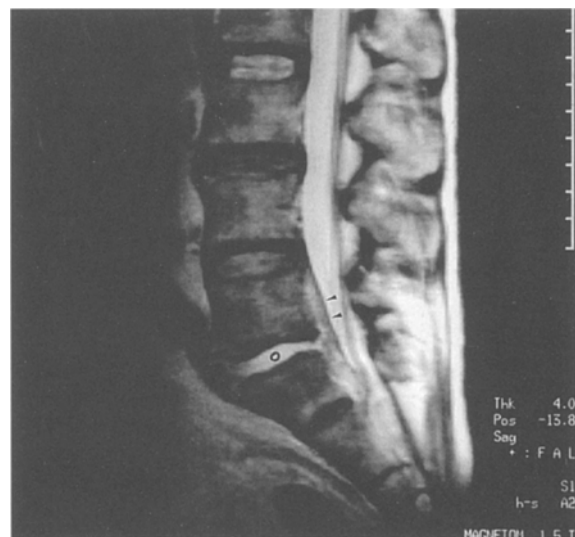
Midsagittal T2-weighted magnetic resonance image on admission. The hyperintense L5/S1 disk (circle) indicates diskitis. Note the posterior displacement of the posterior longitudinal ligament by a hyperintense mass at the same level (arrows).
